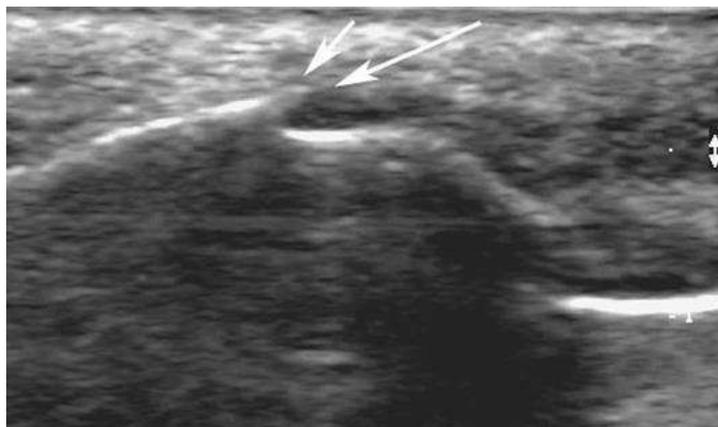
3. Sonogram in a patient with a fractured nasal bone (arrows).
